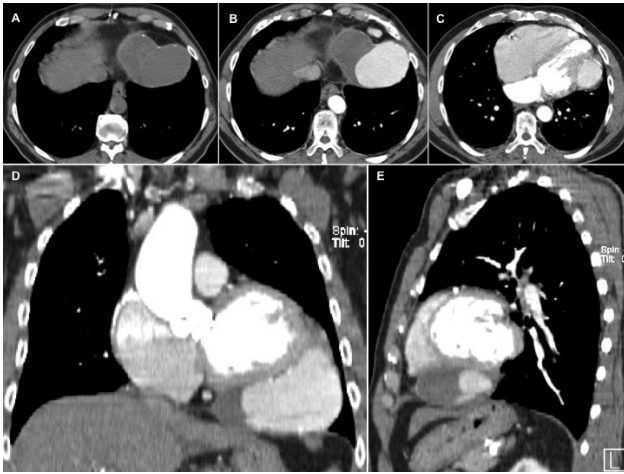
Axial unenhanced CT scan (A) shows a homogeneous mass with dense fluid attenuation, adjacent to infero-lateral left ventricular wall limited by pericardium with small calcifications. Axial contrast-enhanced CT scan (B and C) shows intense partial filling of the lesion with contrast material. D and E images show coronal and sagittal reformations, respectively.
